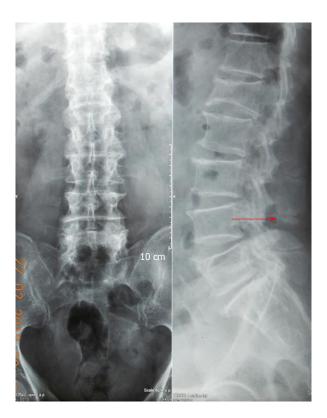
Radiographs of lumbar spine in anterior-posterior and lateral views showing Baastrup's disease at at multiple lumbar level.
